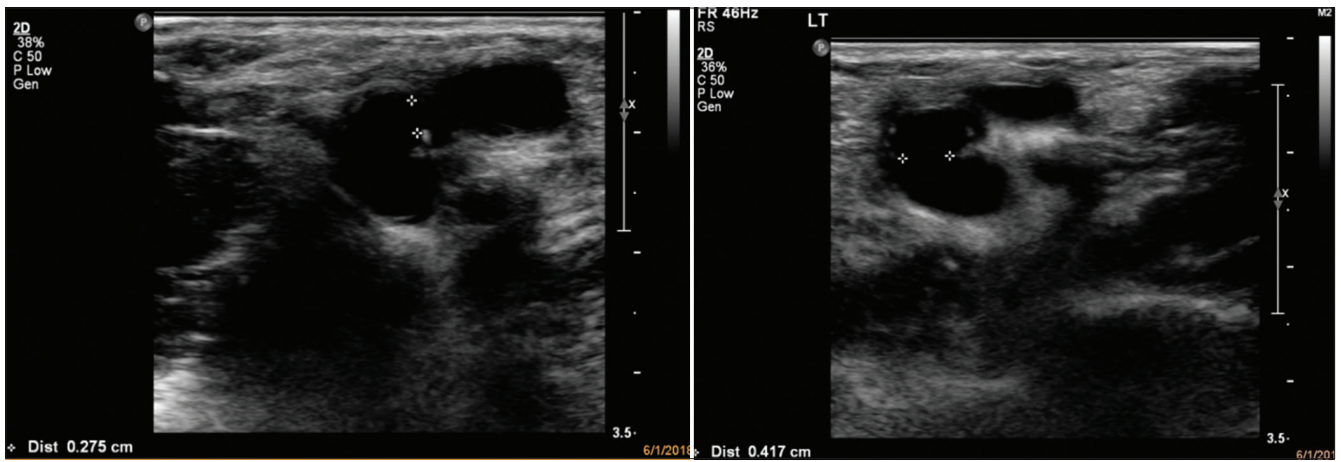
Transverse section of anastomosis diameter measurements using ultrasound B-mode imaging
